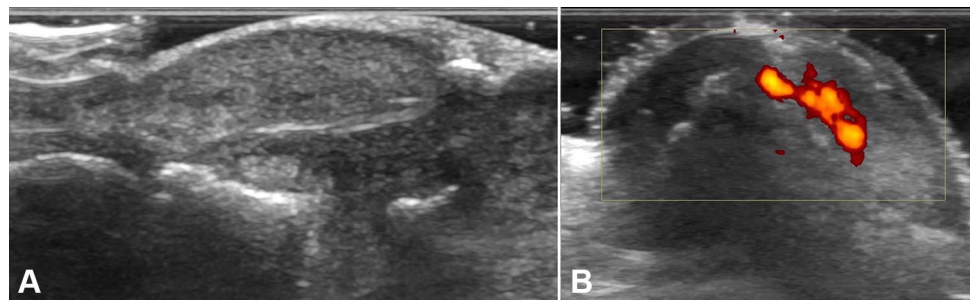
Paronychia. Ultrasound a longitudinal and b transverse views. Areas of increased echogenicity interposed with hypoechoic areas and increased vascularization during power and color Doppler analysis
